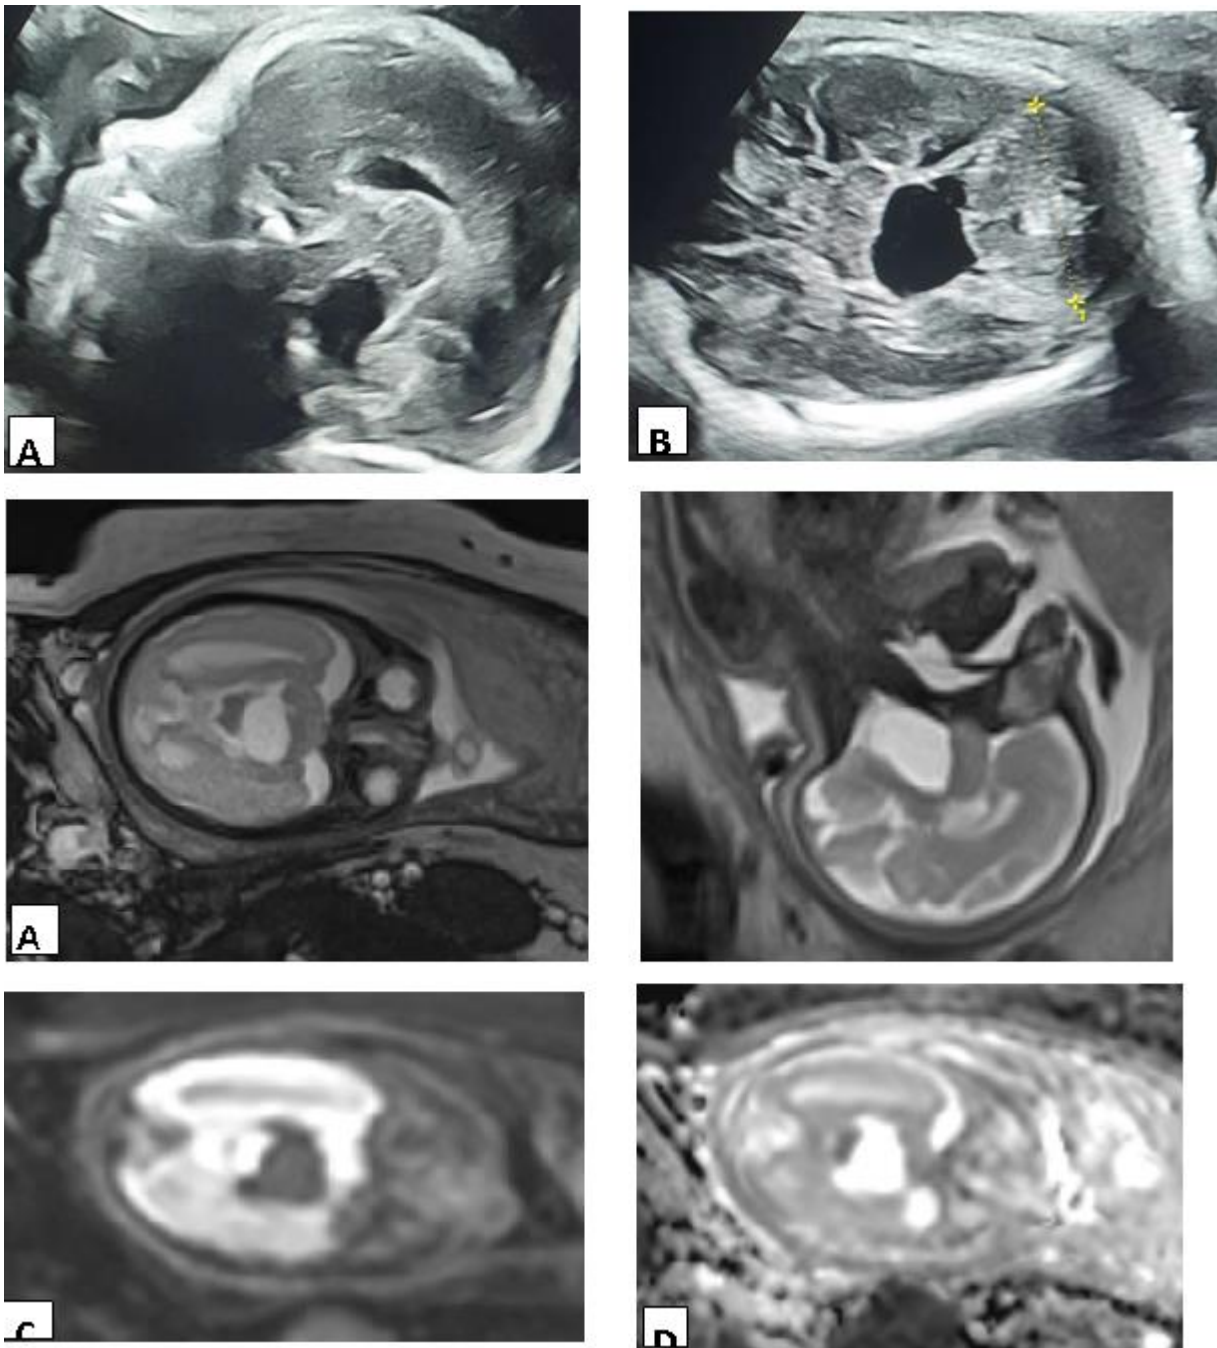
Fetus of 32 weeks gestational age with prenatal US (A and B images) referred as 4th ventricular cystic lesion for differential diagnosis. Prenatal MRI imaging (A=axial T2 HASTE, B=sagittal T2 HASTE) shows a well-defined extra-axial pre-pontine cystic lesion measuring $\pm 23 \times 29 \times 19$ mm. It exhibits hypointense signal at T1WI, hyperintense at T2WI, and hypointense at FLAIR. (C and D images) show facilitated diffusion suggestive of an arachnoid cyst. It causes indentation of the brain stem posteriorly and causes mild dilatation of the ventricular system.
